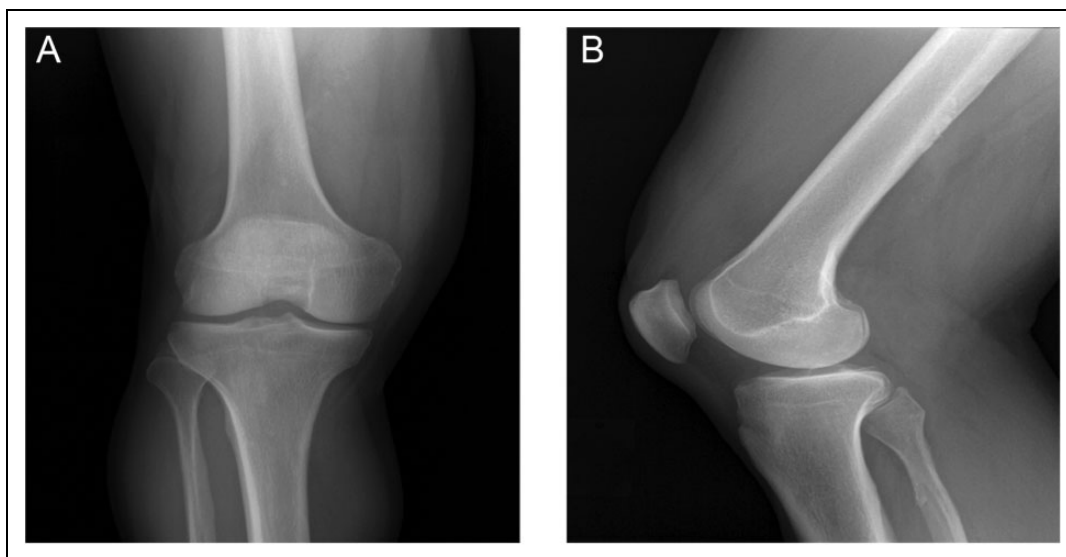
Anteroposterior AP (A) and lateral (B) radiographs of the right knee. There are no significant degenerative changes, although the mineralization in the popliteal fossa on the lateral image suggests the patient may be older in age.
